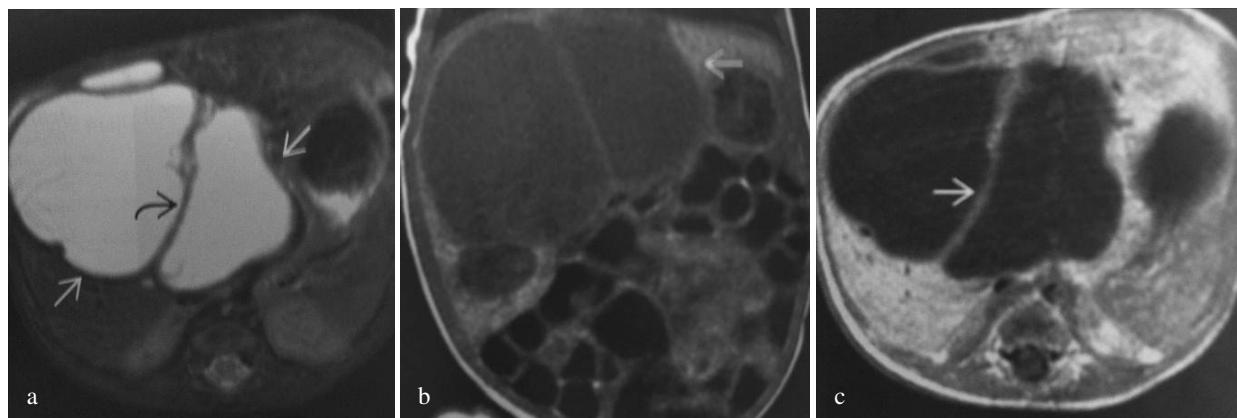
Mesenchymal hamartoma – 2 weeks old boy, diagnosed on a prenatal ultrasound: a) on axial T2-weighted image shows a multicyclic septated mass; b) the hepatic mass in a coronal T1-weighted image before contrast; c) axial T1 weighted-image after gadolinium enhance show the enhance of the thickened septation.
